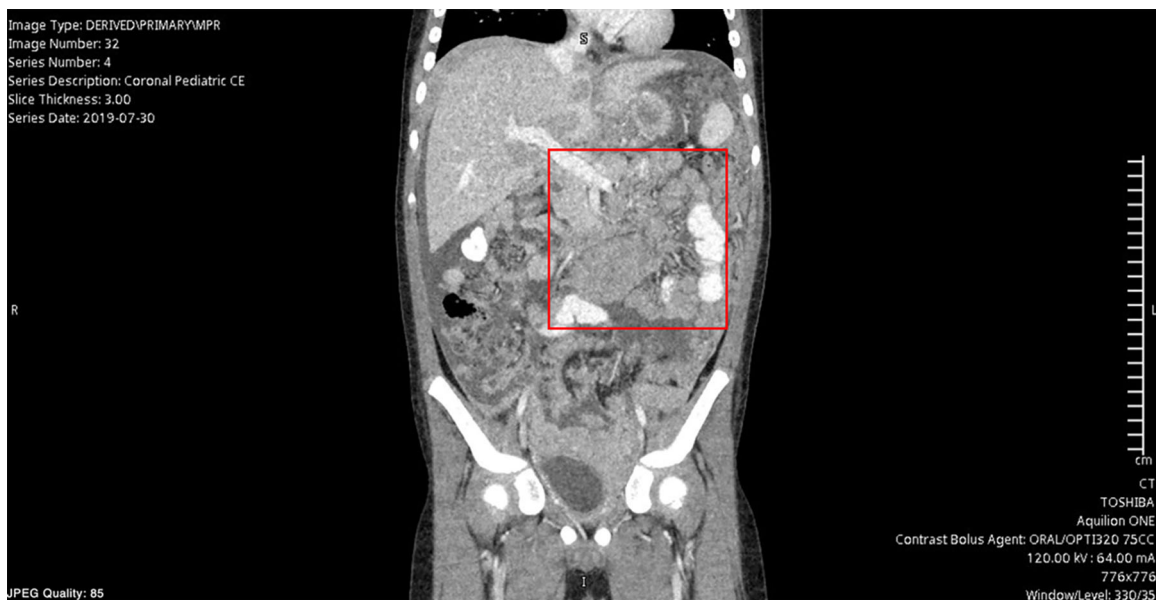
A coronal view on abdominal CT of the mass-like process involving the mesentery and porta hepatis. CT, computed tomography.
